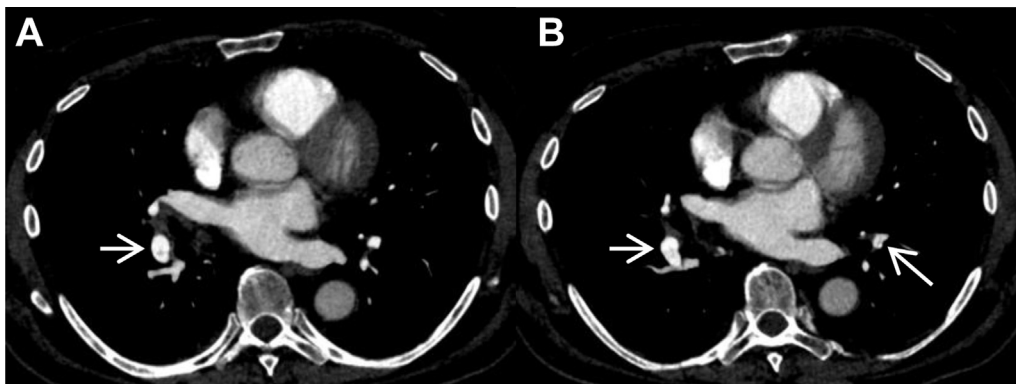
Computed tomography (CT) pulmonary angiography for chest pain and heaviness performed 2 months after thrombolysis of deep venous thrombosis (DVT). A, Web (arrow) in the right lower lobe pulmonary artery compatible with chronic pulmonary embolism. B, Web (arrow) in the right lower lobe pulmonary artery as well as in the left lower lobe at the origin of the anteromedial and lateral basal segmental arteries (arrow) in keeping with chronic pulmonary embolism.
